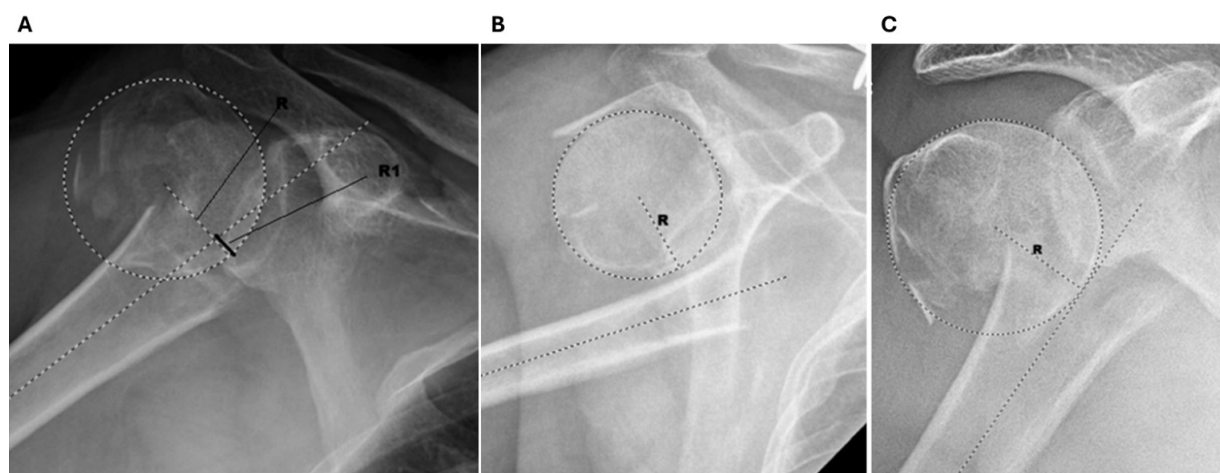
The eccentric head index (EHI) in anteroposterior (AP) shoulder radiographs. The EHI describes the offset of the humeral head center in relation to the diaphyseal axis¹⁵ (A) $EHI = 1 - (R1/R)$, where R represents the diameter of a circle around the humeral head, and R1 represents the eccentric portion of the humeral head outside the humeral shaft axis. In this case, there is humeral head contact with the shaft, and EHI would be typically < 1 . (B) In this case, R1 is 0 since the humeral head is completely displaced from the shaft; hence, $EHI = 1$, indicating complete displacement. (C) In this case, R1 = 0, and EHI is also $= 1$, despite fair contact between the humeral head and the shaft, underscoring the limitations of EHI as a measurement method. Images are original, de-identified radiographs provided by the authors.
